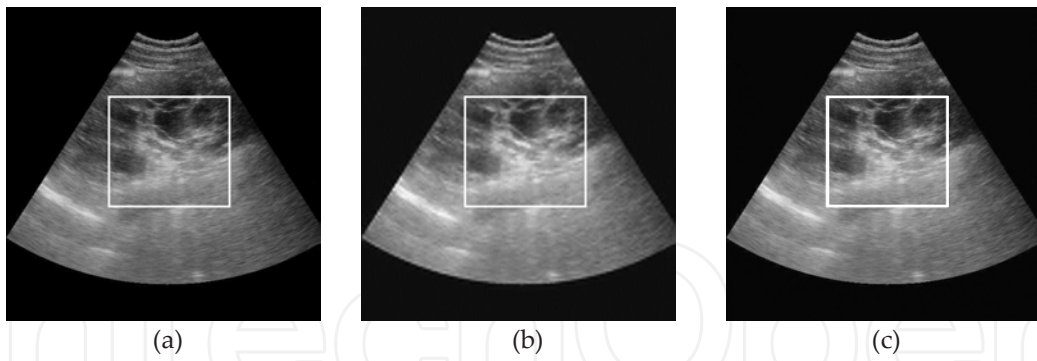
a) Original ultrasound image (b) Despeckled image using the contourlet transform with cycle spinning (c) Denoised image using the proposed linear regression model. The box Indicates the region of image in (b) and (c) showing prominent visual enhancement due to the despeckling.
